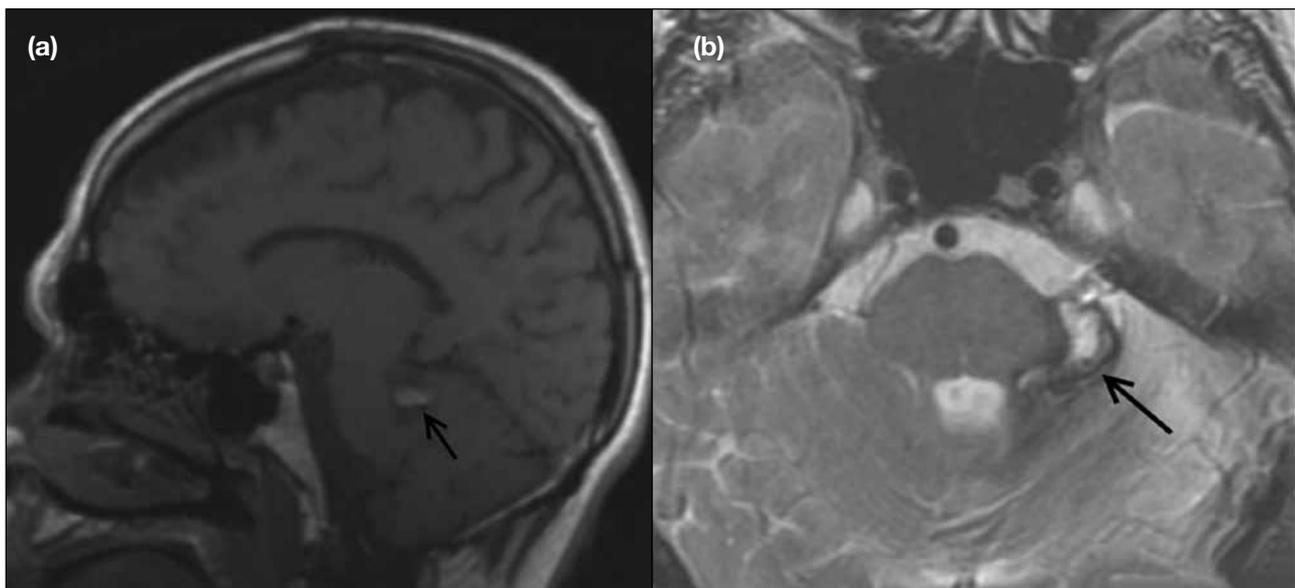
Follow-up magnetic resonance imaging three years post-endovascular embolisation shows marked reduction in the size of the varix (black arrows) with no significant mass effect on (a) the sagittal T1 sequence and (b) the axial T2 sequence. There is no flow void in the residual varix. The slight hyperintense signal on the T1 sequence and hyperintense signal on the T2 sequence within the varix are in keeping with thrombus.
